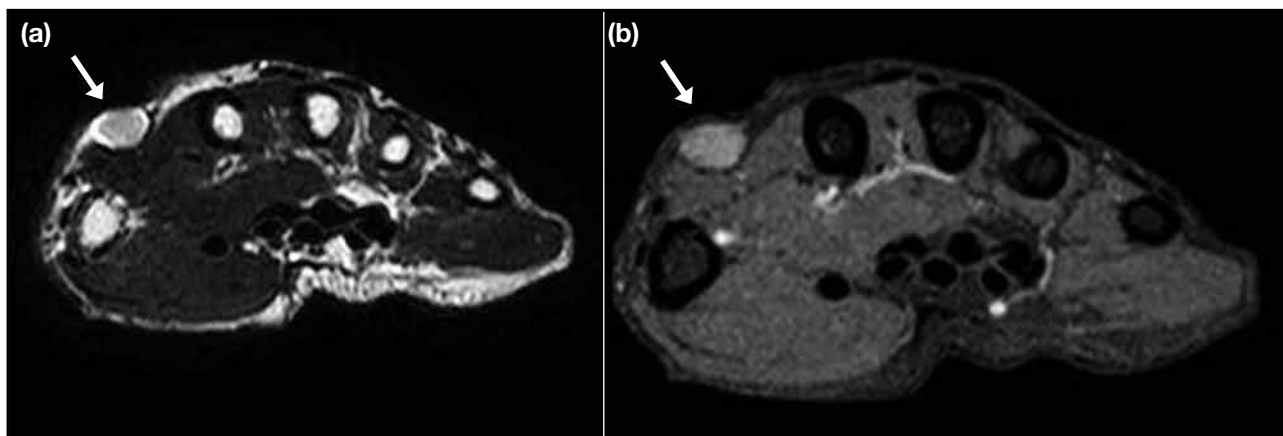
Neurogenic tumour in a 68-year-old woman who presented with first webspace nodule: (a) T2-weighted axial magnetic resonance image showing an oval hyperintense lesion (arrow) in the subcutaneous tissue of the dorsal aspect of the first webspace. (b) T1-weighted post-contrast fat-saturated magnetic resonance image showing corresponding contrast enhancement. It is seen to be closely related to a tubular structure, probably the superficial branch of the radial nerve (not shown).
